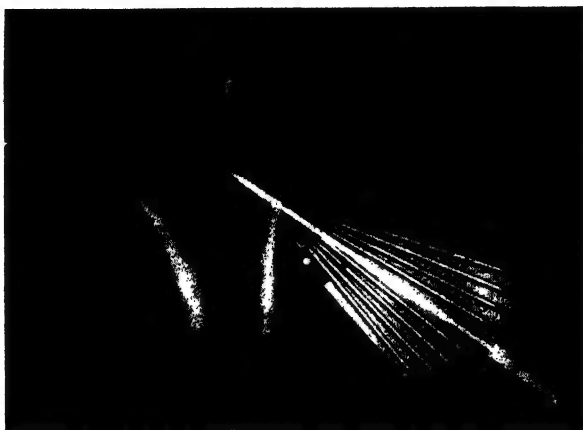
The Engel-May guide as it appears in the A.P. radiograph. Note its attachment to the trochanter by the central pin.
